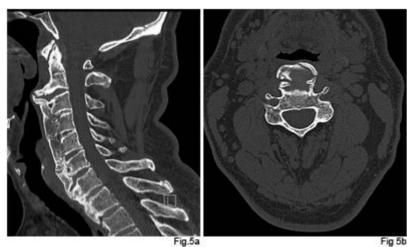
(1.5 column fitting): Pre-operative CT imaging with C2-6 anterior osteophytes and C2-4 tracheal compression in a) saggital and b) transverse sections
